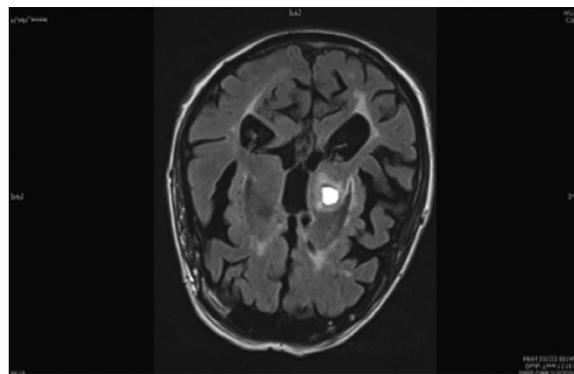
Axial FLAIR image of the lesion.
